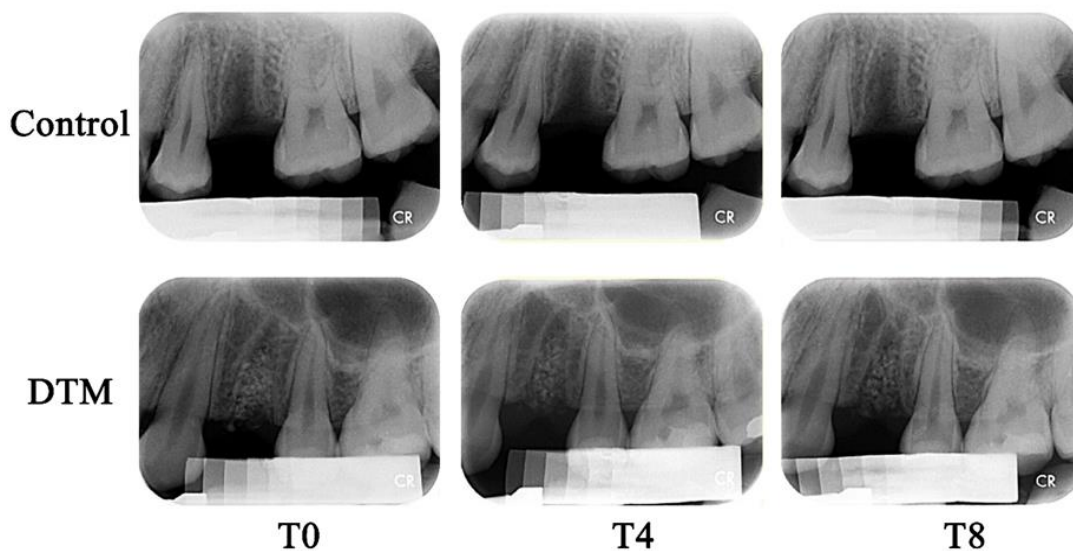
The radiographs of the socket sites after extraction (T0), at 4th week (T4), and at 8th week (T8)
